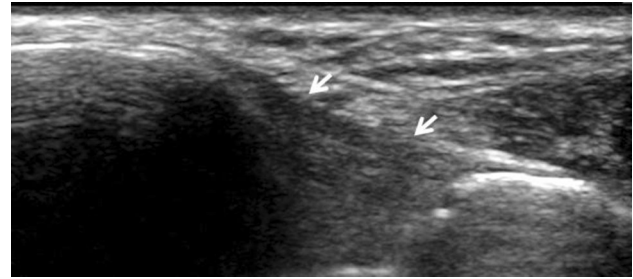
Anterior axial sonographic image obtained at the level of the tibiofibular syndesmosis (*panoramic image*): the anteroinferior tibiofibular ligament is seen as a moderately thick echogenic band on the anterior aspect of the joint (*arrows*)
